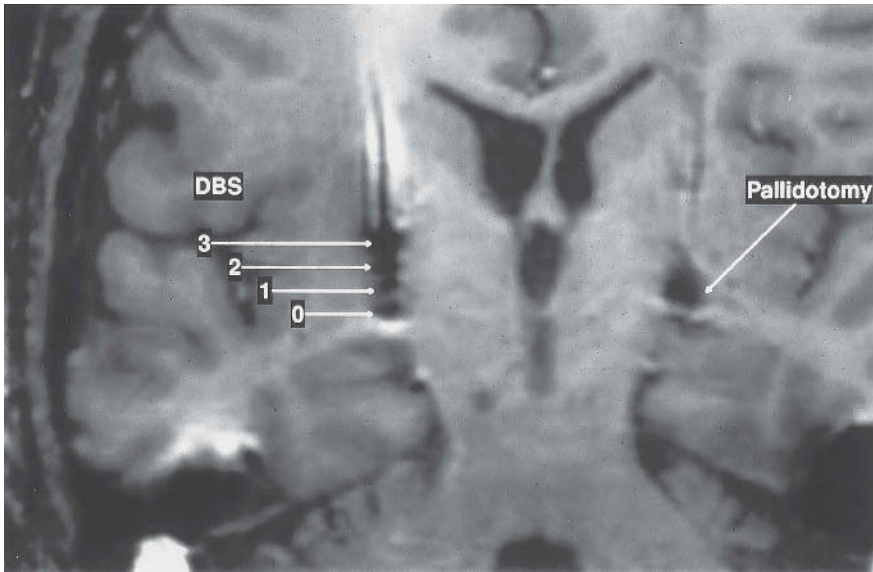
A coronal MRI of an old left pallidotomy and a newly placed right DBS. A large number of unilateral pallidotomies are now being combined with DBS on the contralateral side. The DBS has the advantage of adjustability and seems to avoid many of the complications seen with bilateral pallidotomy.
